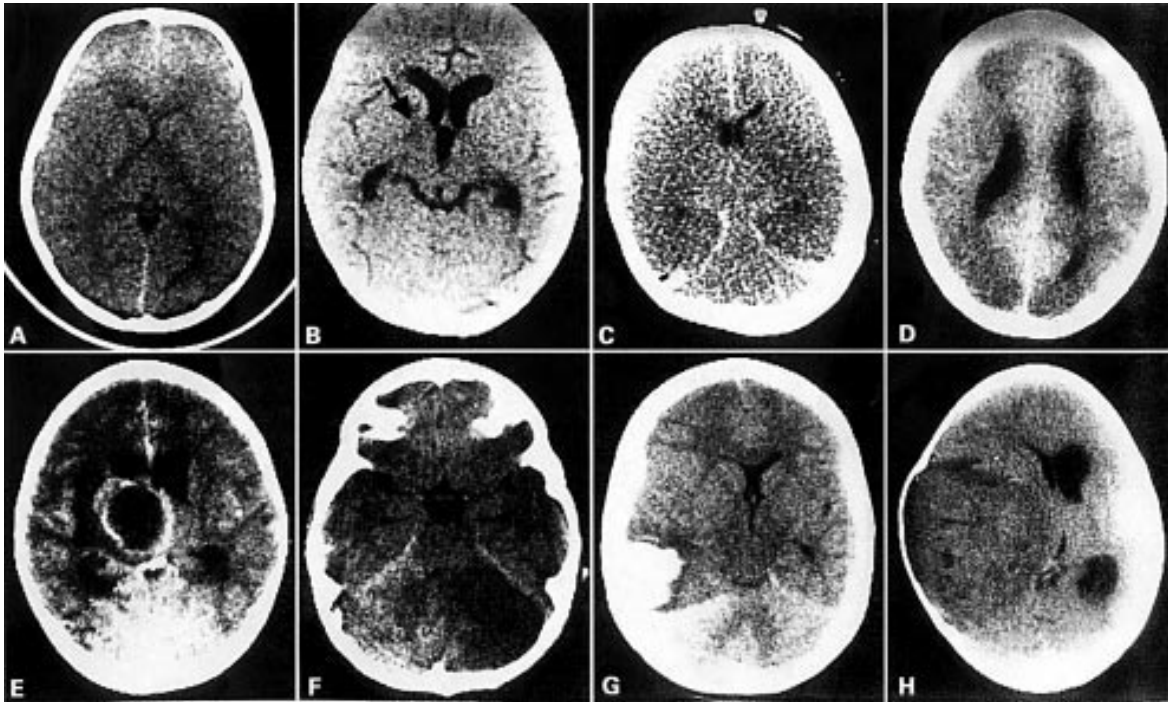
CT scan abnormalities commonly seen in unconscious children (A) Small ventricles suggestive of acute brain swelling in a patient in acute coma. (B) Acute hydrocephalus in a patient with a reduced level of consciousness after status epilepticus. There is a small infarct in the basal ganglia on the left, indicated by the arrow. CSF showed a pleiocytosis and acid fast bacilli; the child responded to antituberculous therapy. (C) Low density in the cerebral hemispheres compared with the posterior fossa, suggestive of widespread ischaemia. There is high density in the falx suggestive of blood and it is likely that this child has been shaken. (D) Bilateral anterior and posterior watershed infarcts in a child with hypertensive encephalopathy in whom blood pressure had been reduced precipitously. (E) Contrast enhanced CT scan showing a cerebral abscess in a child with a hemiparesis, a reduced level of consciousness, and a fever. (F) Low density in the right cerebellum compatible with an infarct in a child with an acute vertebralbasilar dissection. (G) CT scan without contrast showing a left sided intracerebral haematoma in a child with an arteriovenous malformation. (H) Large supratentorial tumour and acute hydrocephalus.
